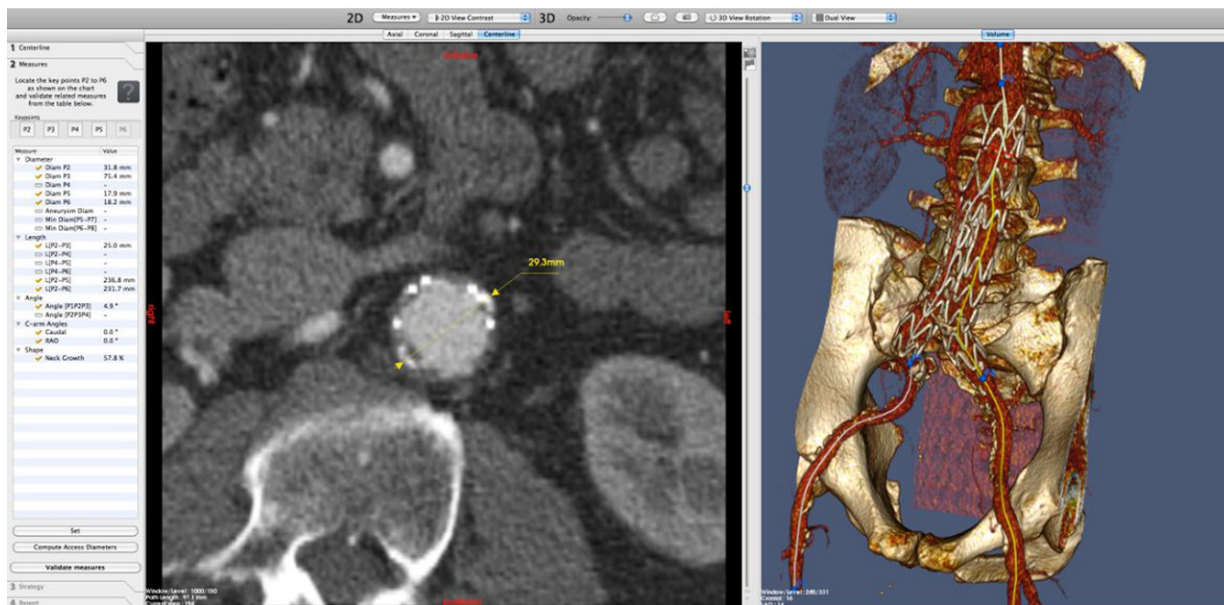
Computed tomography angiography analysis using the Endosize software. Outer-to-outer diameters were measured perpendicularly to the centerline.
